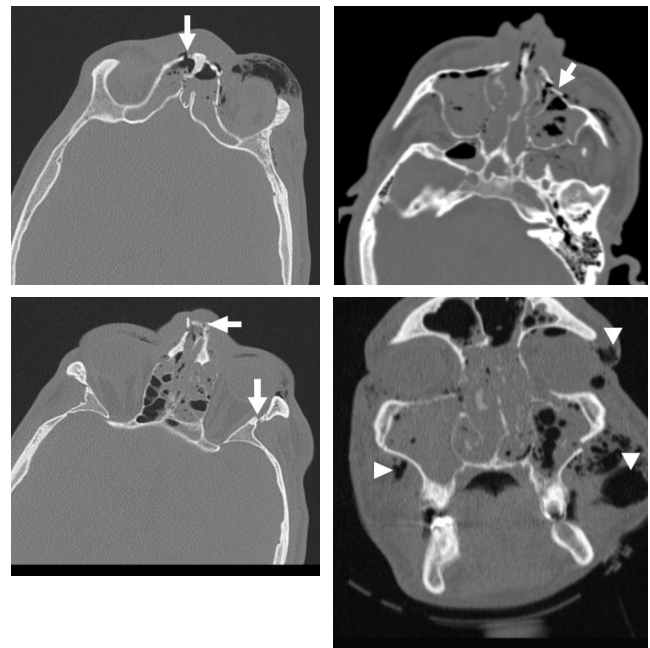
In a 45-year-old male patient fractures (arrows) in the maxillary bone, the ethmoid bone, nasal septum and frontal bone in the axial (a, b,c) and coronal (d) sections of unenhanced maxillofacial CT performed under emergency conditions following traffic accident. Significant air was observed under the skin secondary to trauma (arrowheads).
